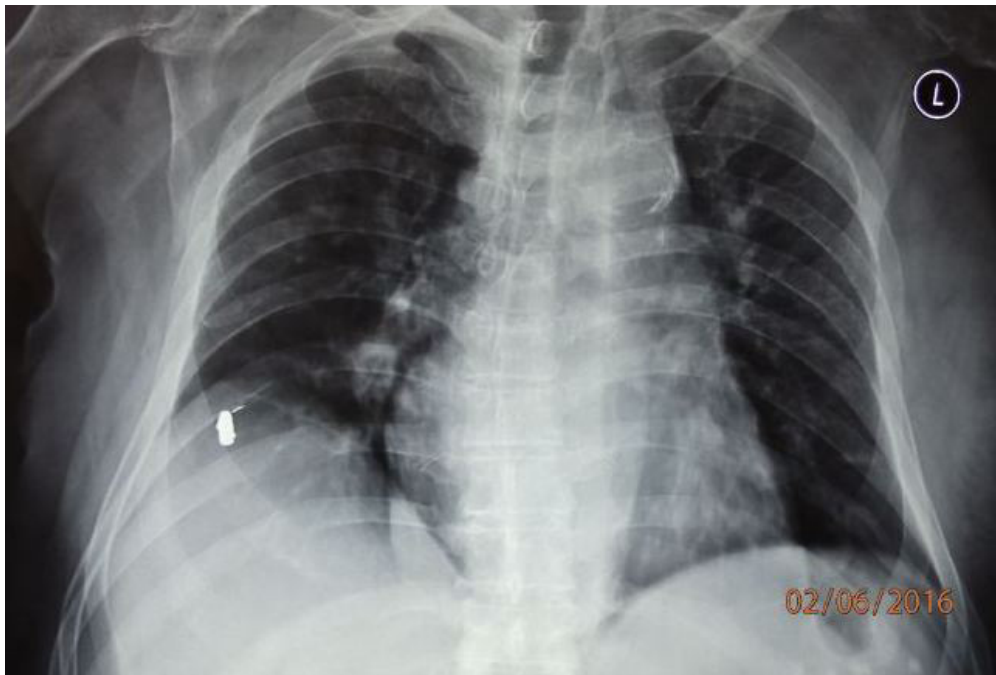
Chest X-ray showing a bullet in the projection of right VIII intercostal space
